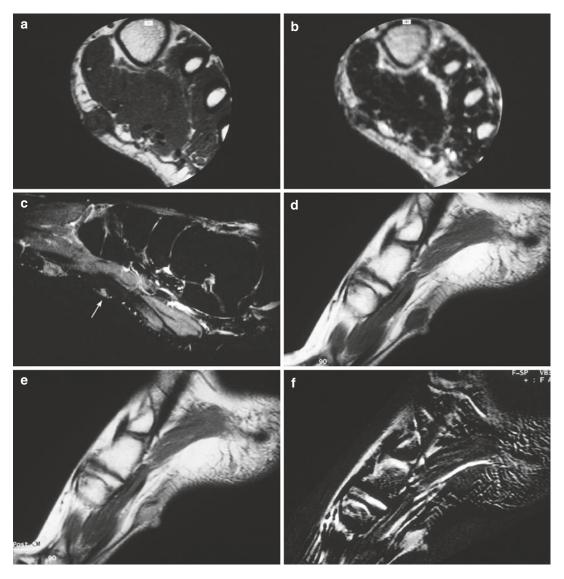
(\mathbf{a} - \mathbf{f}) Two cases of plantar fibromatosis in a 37-year-old-man (\mathbf{a} - \mathbf{c}) and in a 13-year-old girl (\mathbf{d} - \mathbf{f}). (\mathbf{a}) Axial spin-echo T1-weighted MR image. (\mathbf{b}) Axial turbo spin-echo T2-weighted MR image. (\mathbf{c}) Sagittal STIR MR images. (\mathbf{d}) Sagittal spin-echo T1-weighted MR image after gadolinium contrast injection. (\mathbf{f}) Sagittal subtraction MR image. Subcutaneous nodular lesion of intermediate signal intensity at the sole of the foot in apposition with the plantar
